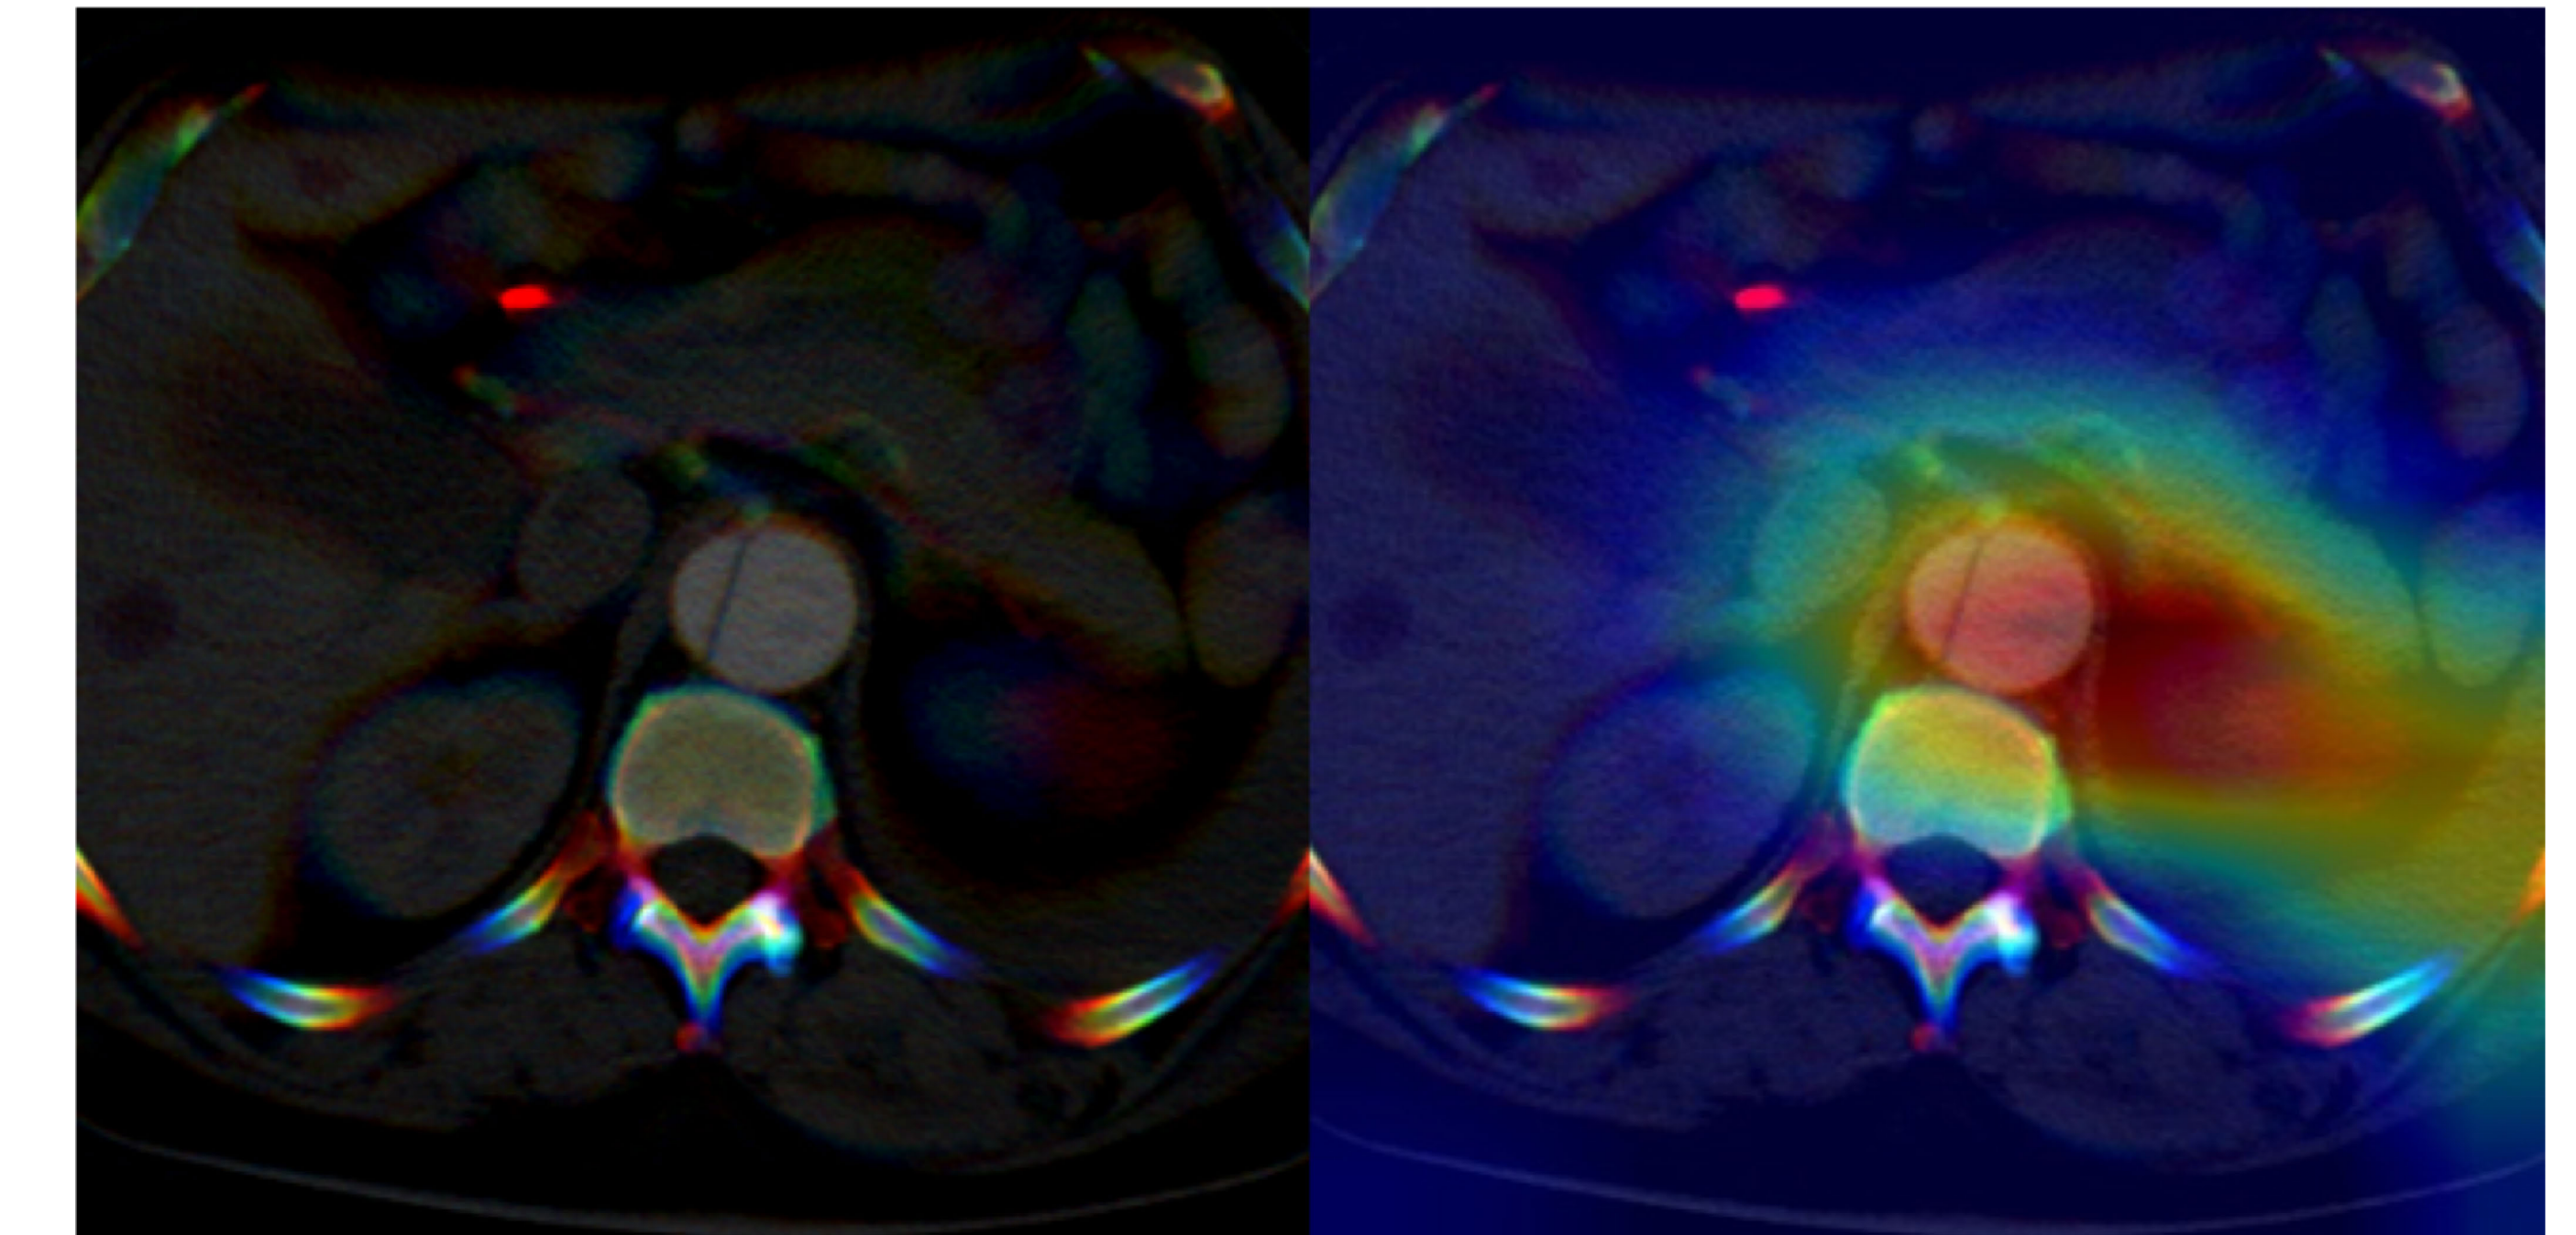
Stanford Type B aortic dissection axial CTA with colored augmentation (left) and corresponding Class Activation Map¹⁶ (CAM) (right)
